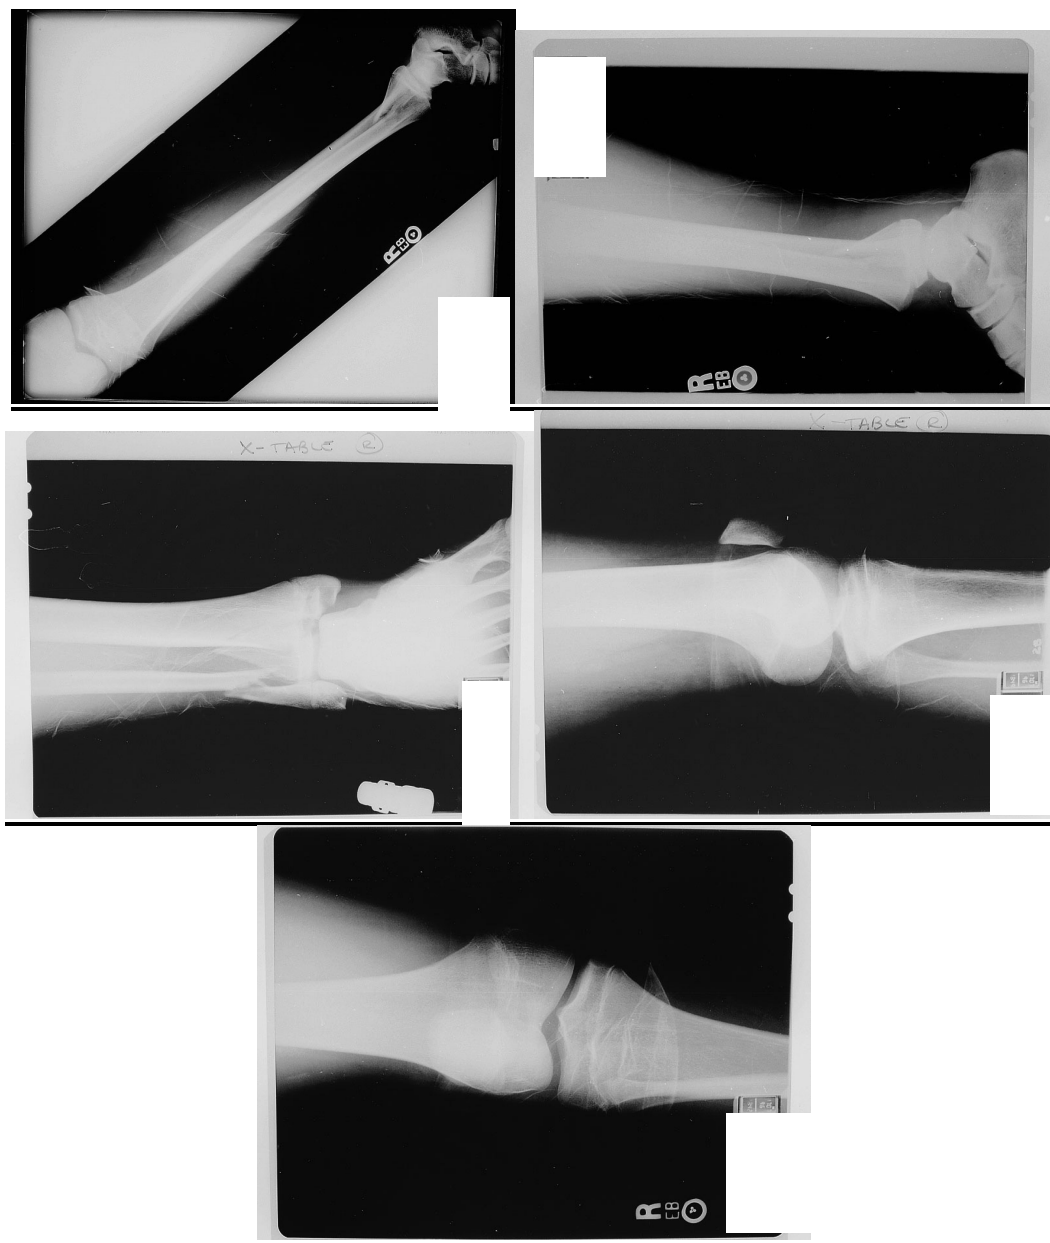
Radiographs from PWC File 13.
